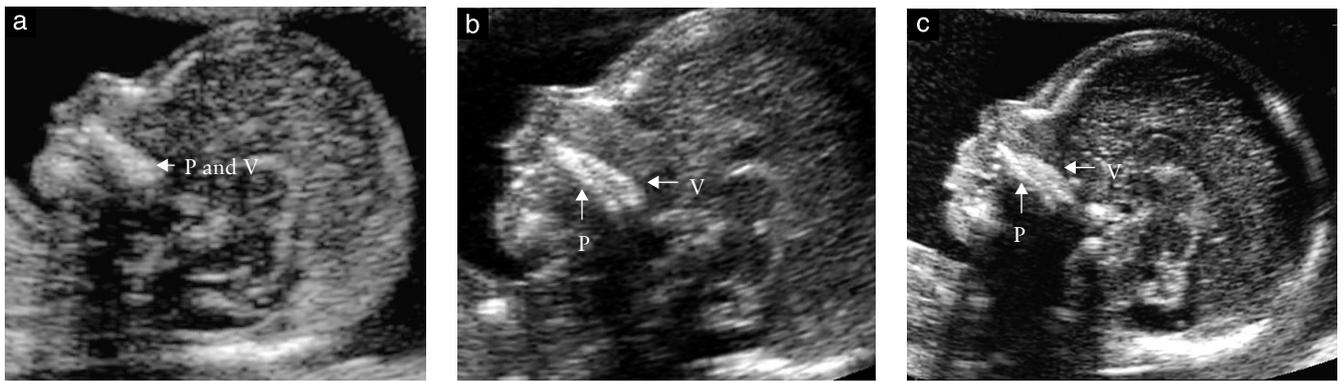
Ultrasound images of a normal fetal profile at 12 weeks (a), 16 weeks (b) and 20 weeks (c) of gestation. At 12 weeks the palate (P) and vomer (V) appear as a single hyperechogenic rectangular structure, but in the second trimester there are two echogenic structures. The inferior one, which is directed towards the basilar portion of the occipital bone posteriorly, represents the palate. The vomer is the superior one, with an irregular convex shape on the top, and is directed towards the sphenoid bone posteriorly.
